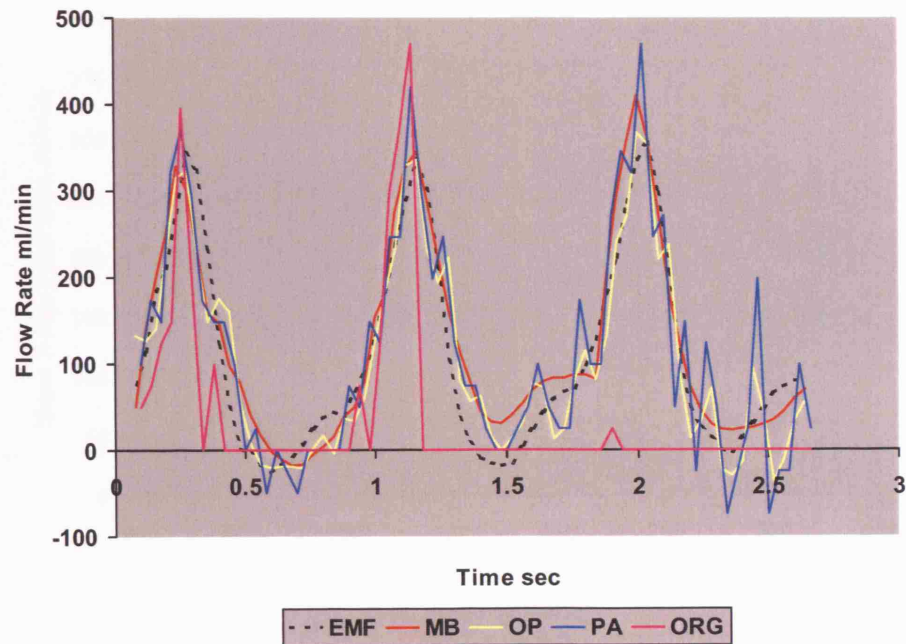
Prosthetic vascular graft experiments: An example of x-ray calculated and EMF waveforms for the CPU graft. The mean EMF flow rate was 107 ml/min.
